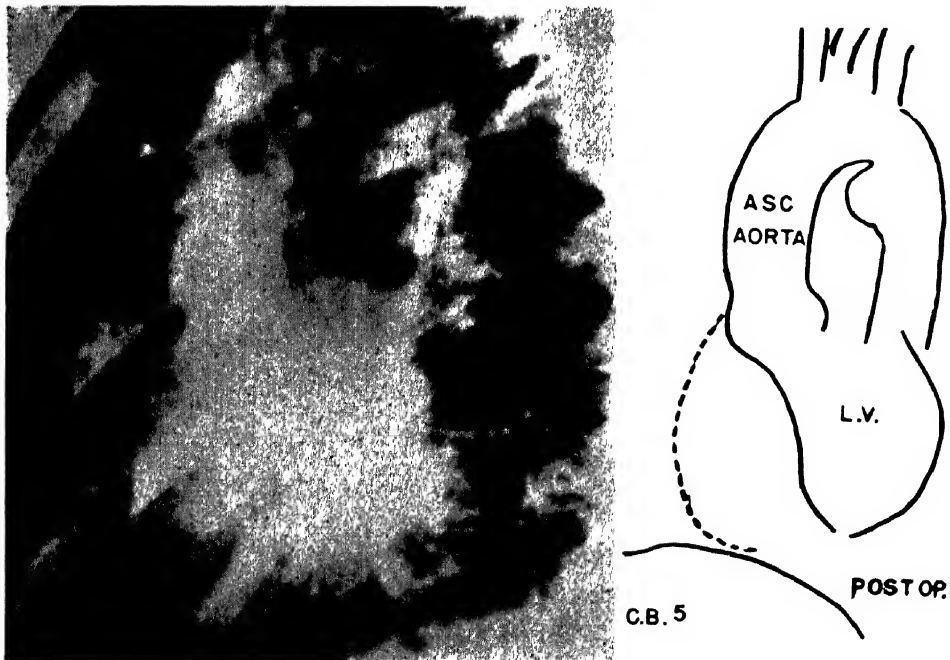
Female, aged 21. Patent ductus arteriosus (operated). Postoperative angiogram showing aneurysmal dilation of the proximal descending aorta. This probably represents a traction aneurysm of the aorta. Preoperatively, angiogram showed a more diffuse dilation. (M. F. Steinberg, A. Grishman, and M. L. Sussman: *Am. J. Roentgenol.*)
